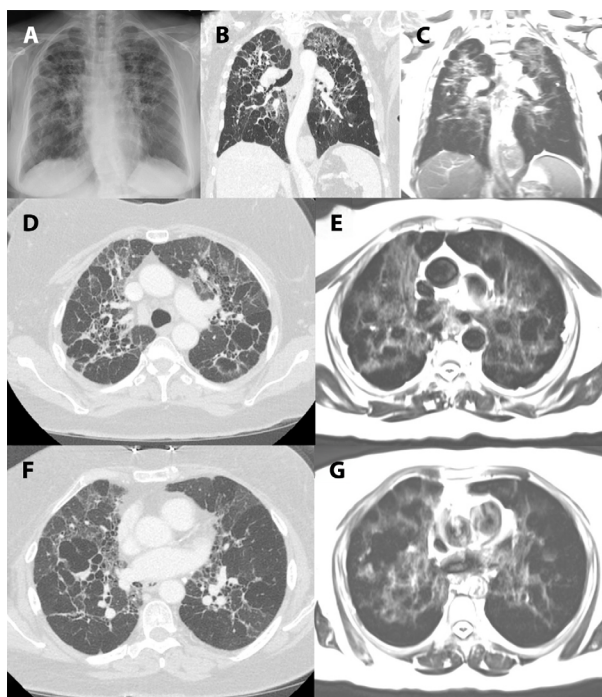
57-year-old woman with Stage IV pulmonary sarcoidosis and stage IV chest x ray (A). Axial (D and F) and coronal (B) chest CT images with corresponding axial (E and G) and coronal (C) T2 HASTE images show upper lobe predominant reticulation and traction bronchiectasis consistent with fibrosing interstitial lung disease.
